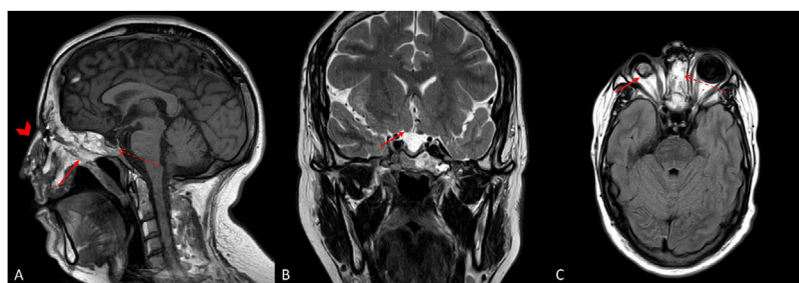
(A) Sagittal T1 weighted sequence showing absent nasal cavity and high arched palate due to confluence of maxilla, sphenoid and ethmoid bones (red arrow). Hypophyseal atrophy (dashed arrow) and surgical nasal reconstruction (arrowhead) are also noted. (B) Coronal T2 sequence reveals markedly atrophic right optic nerve (red arrow). (C) Axial FLAIR demonstrating right microphthalmia (red arrow) and absent ethmoid pneumatization (dashed arrow).
